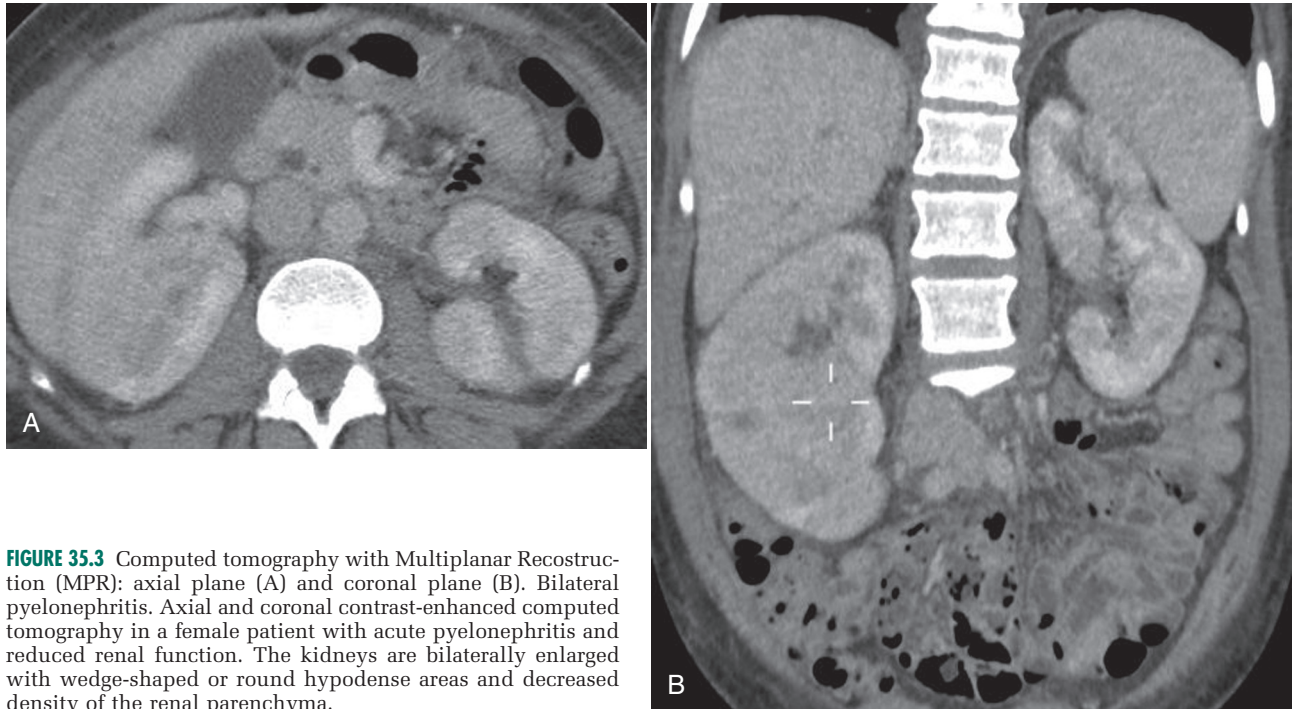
Computed tomography with Multiplanar Reconstruction (MPR): axial plane (A) and coronal plane (B). Bilateral pyelonephritis. Axial and coronal contrast-enhanced computed tomography in a female patient with acute pyelonephritis and reduced renal function. The kidneys are bilaterally enlarged with wedge-shaped or round hypodense areas and decreased density of the renal parenchyma.
